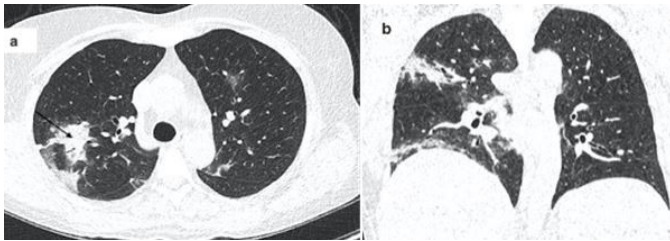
A-29-year old male patient with cough and fever. After the onset of symptoms; bilaterally peripheral ground-glass opacities are seen (a), (b) with black arrow in lung window of Thorax CT. There is no consolidation that has been seen in mediastinum window.
